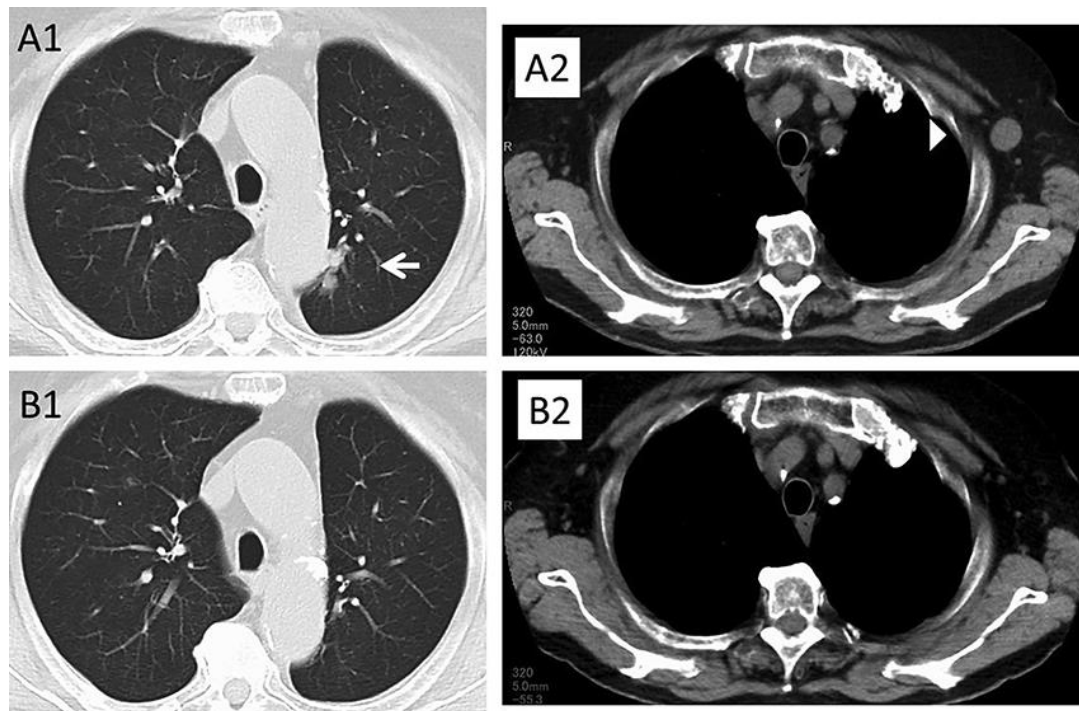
Chest computed tomography (CT) before and after nivolumab administration. (A1, A2) CT image before nivolumab administration revealing pulmonary metastasis (arrow) and left axillary lymph node metastasis (arrowhead). (B1, B2) CT image 9 months after nivolumab administration.
